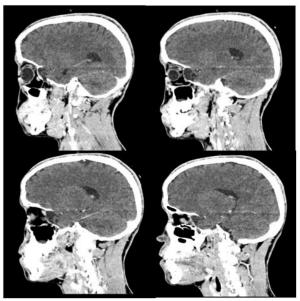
Sagittal CT scan (soft tissue window) showing herniation of the dura mater into the orbit through the sphenoid aplasia, displacing retrobulbar muscular structures
